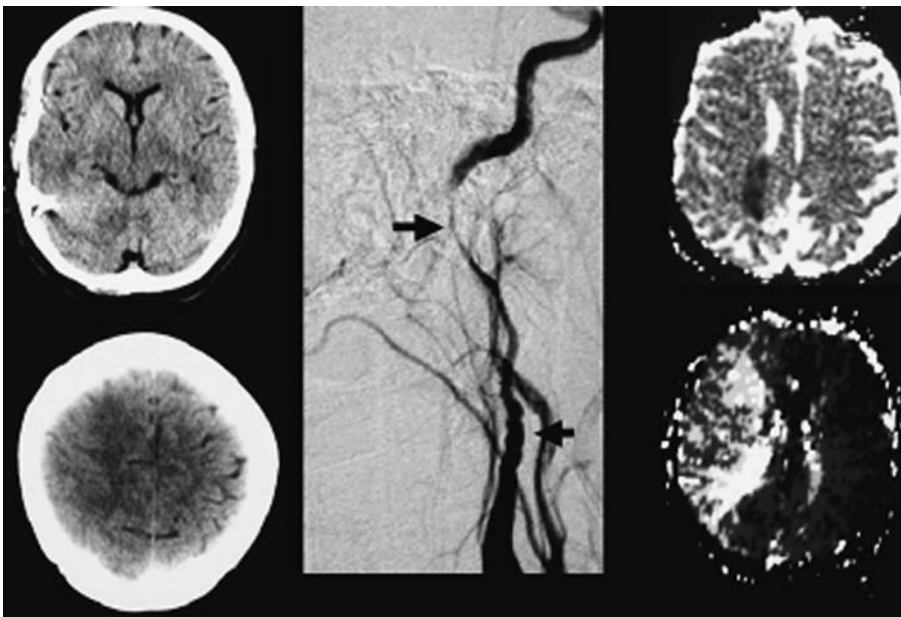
Computed tomography (left), digital subtraction angiography (DSA, middle) and MRI (right) of a patient with internal carotid artery dissection. Note diffuse swelling of the frontal-parietal cortex on CT on day three after onset of symptoms. At this time point the patient suffered from a severe left hemiparesis. DSA shows classical “string sign” of cervical artery dissection with continuous narrowing of arterial lumen. MRI: ADC map (upper images) on day three after onset of symptoms shows small area of ischemia (dark). Time-to-peak parameter image (lower images) shows delayed contrast inflow to the entire right MCA territory. The patient underwent stent protected dilatation of the arterial stenosis 6 days after symptom onset and recovered almost completely from the severe hemiparesis. (Courtesy of Prof. VON KUMMER)
